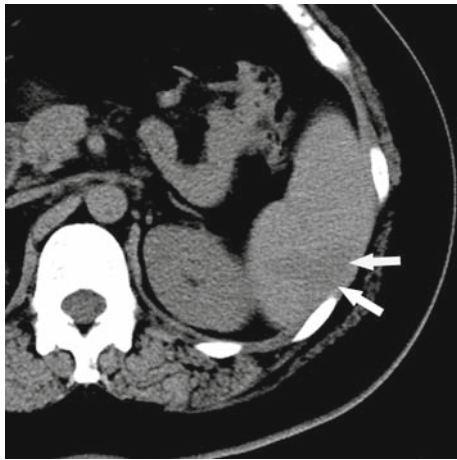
Splenic infarction in a 29-year-old woman with infectious mononucleosis. The patient presented with fever of 38.9°C (102°F) and acute upper left quadrant pain after 7 days of remittent fever and chills. Noncontrast computed tomography (CT) shows a wedge-shaped area of low density in the dorsal portion of the spleen (*arrows*)
